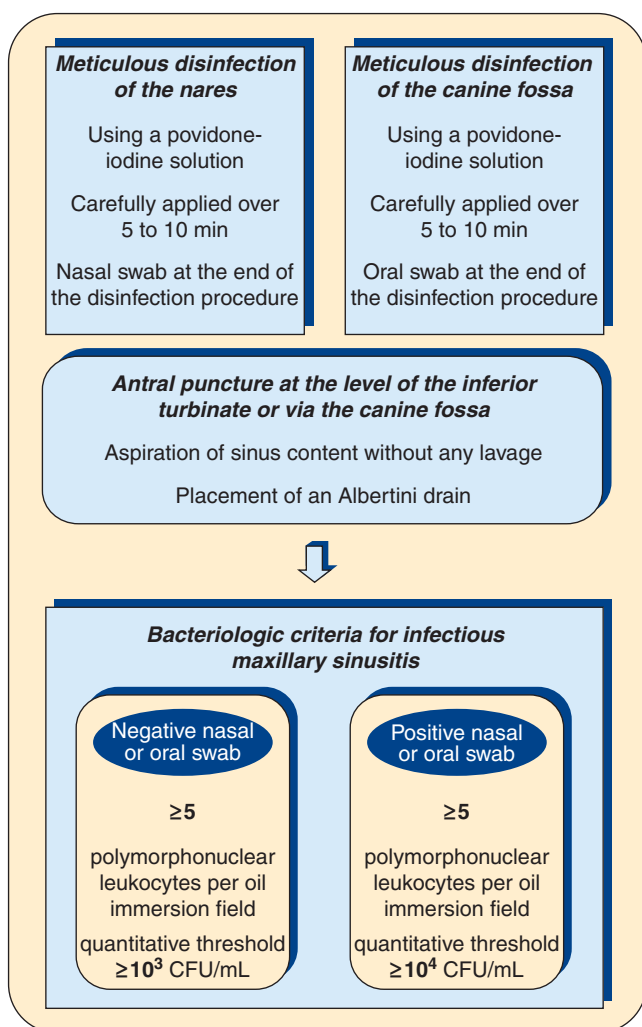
Chart summarizing a logical diagnostic approach and proposing criteria for infectious maxillary sinusitis. (Reproduced, with permission, from Lichtenstein D, Biderman P, Meziere G, et al. The “sinuso-gram”, a real-time ultrasound sign of maxillary sinusitis. *Intensive Care Med.* 1998;24:1057–1061. With kind permission from Springer Science and Business Media.)
